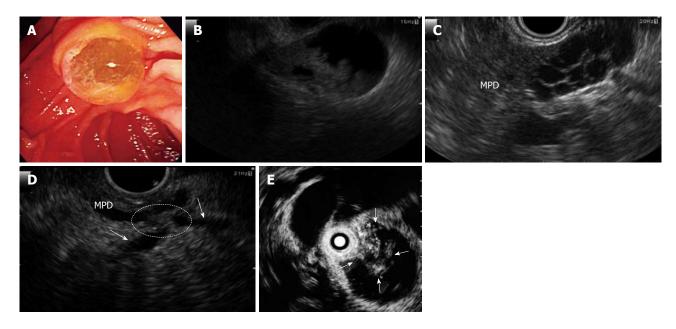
Intraductal papillary mucinous neoplasms (IPMN). A: An endoscopic diagnosis of an IPMN can be established if the "fish-eye" ampulla is visualized in minority cases; B: IPMN of main duct type. EUS shows a mural nodule within by the mucinous dilatation of the pancreatic ducts, with involvement of the main duct at the tail of the pancreas; C: IPMN of side branch type. EUS shows a multiple dilatation of the side branch at the neck of the pancreas; D: IPMN of the combined type. EUS show a mural nodule stretching (circle) over the main pancreatic duct and side branches (arrows) at the body of the pancreas. E: IPMN of main duct type. Intraductal ultrasonography (IDUS) can identify tumor nodule development into the main pancreatic duct (arrows). MPD: Main pancreatic duct.
